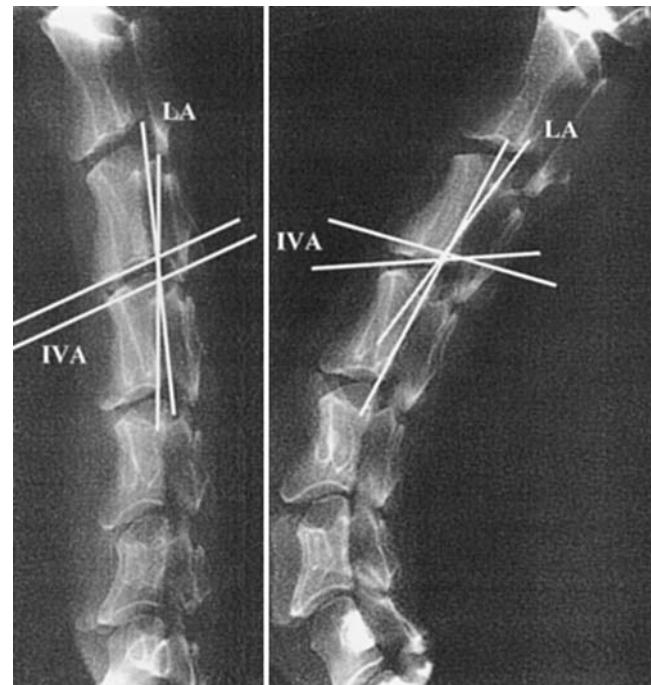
The C3–4 motion segment was evaluated using lateral digital functional radiography in flexion (*left*) and extension (*right*). Flexion–extension differences of IVA and LA were calculated.
